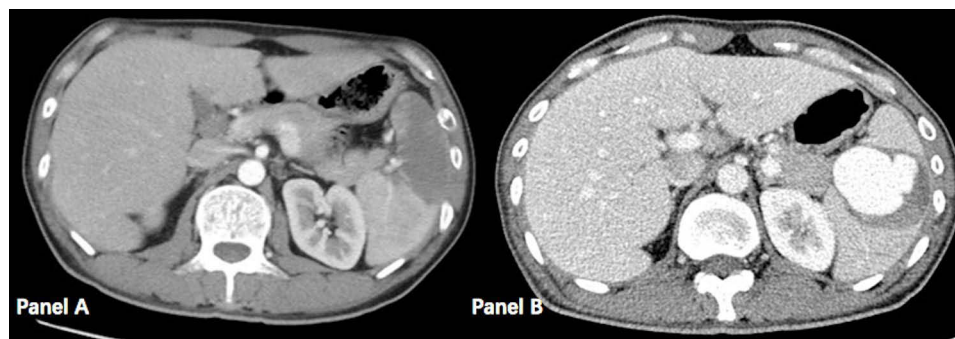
Abdominal computed tomography (Panel A shows splenic infarction, Panel B shows subsequent splenic artery aneurysm in the splenic infarction area).
